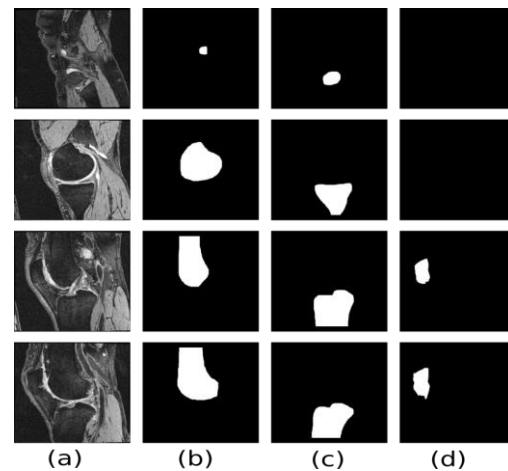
Original image with the ground-truths. (a) MR image sequence, (b) Femur bone mask, (c) Tibia bone mask, and (d) Patella bone mask
